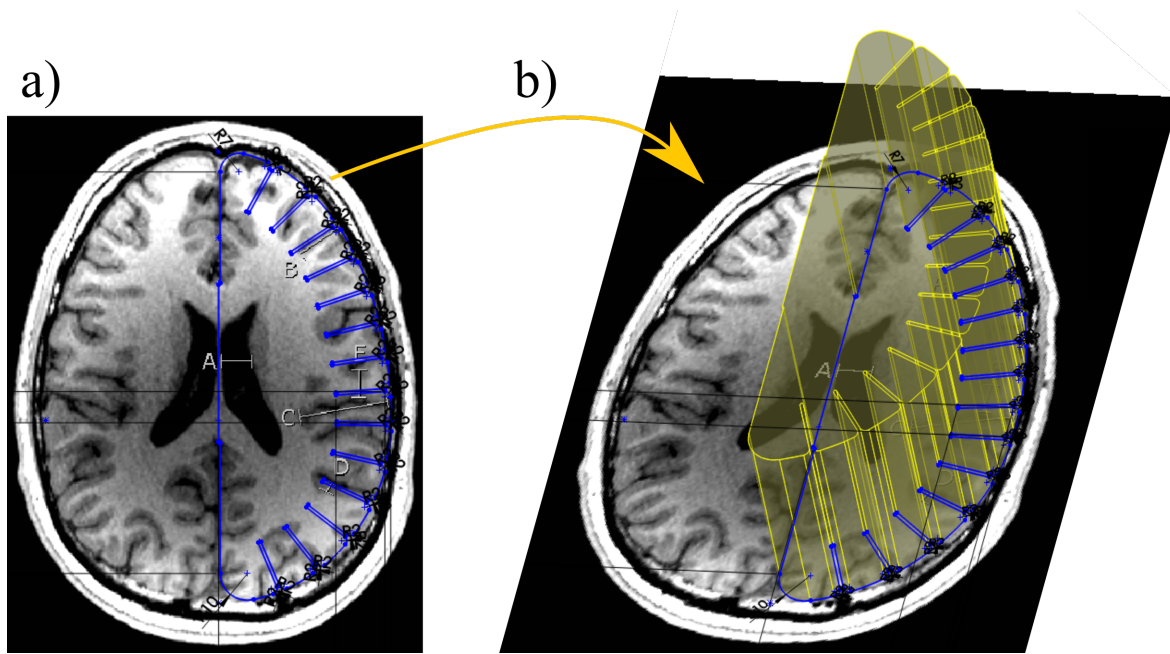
The axial MRI image used for the construction of the biofidelic test object. Embedded lettering corresponds to dimensions of significant anatomical features:
